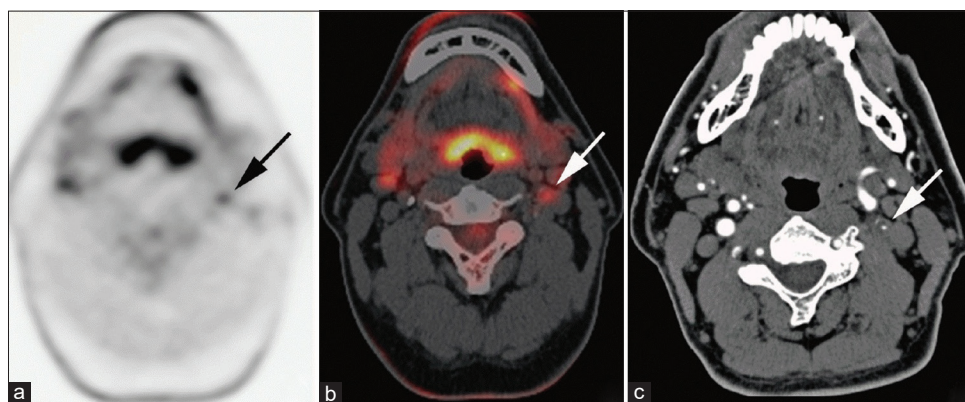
Transaxial ^{18}F -FDG Positron emission tomography alone image (a) and positron emission tomography/computed tomography image (b) demonstrating high uptake in the left internal carotid artery. Computed tomography angiography image (c) demonstrating severe stenosis of the left internal carotid artery with an atherosclerotic plaque
